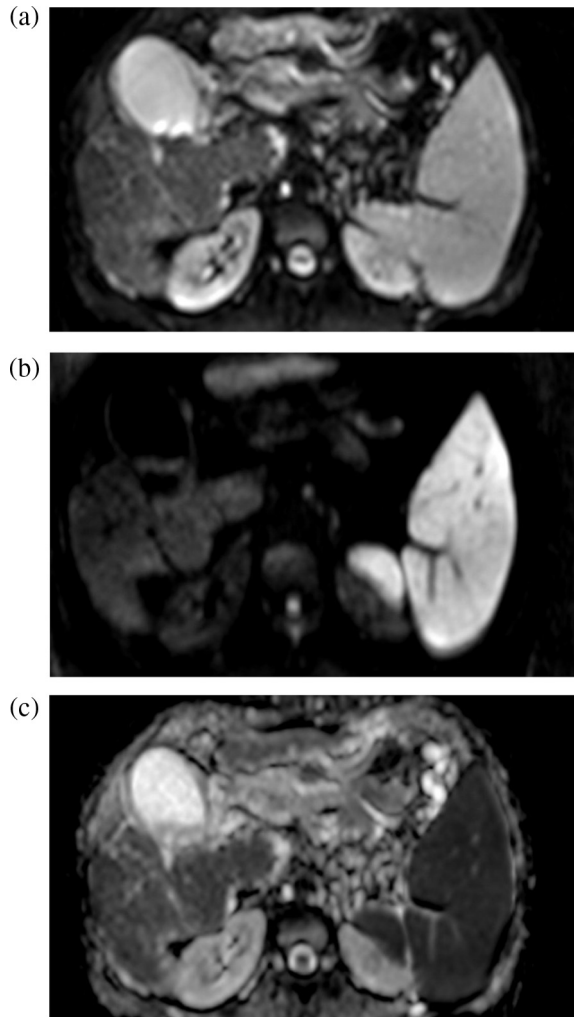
DWI at  $b = 0$  (a),  $b = 500$  (b), and ADC map (c) for a patient with stage 4. Liver ADC =  $1.54 \times 10^{-3} \text{ mm}^2/\text{s}$ , S-ADC = 1.20 and R-ADC = 0.60.
